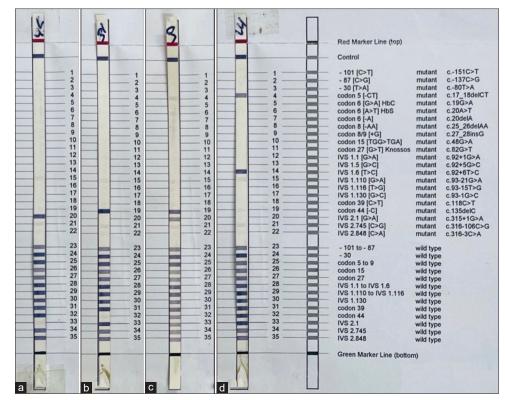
Results of the β-thalassemia mutations detected by ViennaLab strips used in the current study. (a) Homozygous IVSII-1 (G>A), (b) Homozygous codon 44 (-C), (c) Compound heterozygous codon 44 (-C)/IVSII-1 (G>A), (d) Compound heterozygous codon 5 (-CT)/IVSI-6 (T>C)
